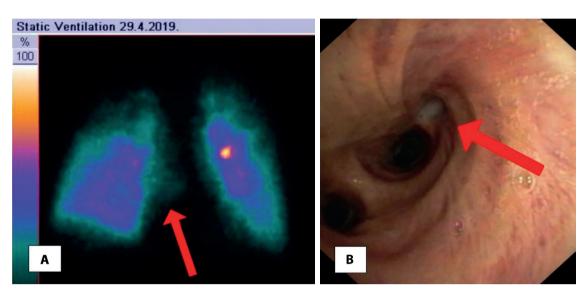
Ventilation scintigraphy (image a) shows an increased accumulation of inhaled radioactive aerosol in the right retrocardiac region, suggesting a ventilated part of the pulmonary parenchyma of an accessory cardiac bronchus (red arrow). Bronchoscopy (image b) shows the origin of the ACB filled with a large amount of mucus (red arrow).
